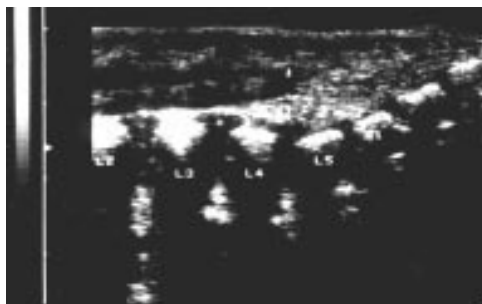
Ultrasonographic appearance of conus medullaris.
